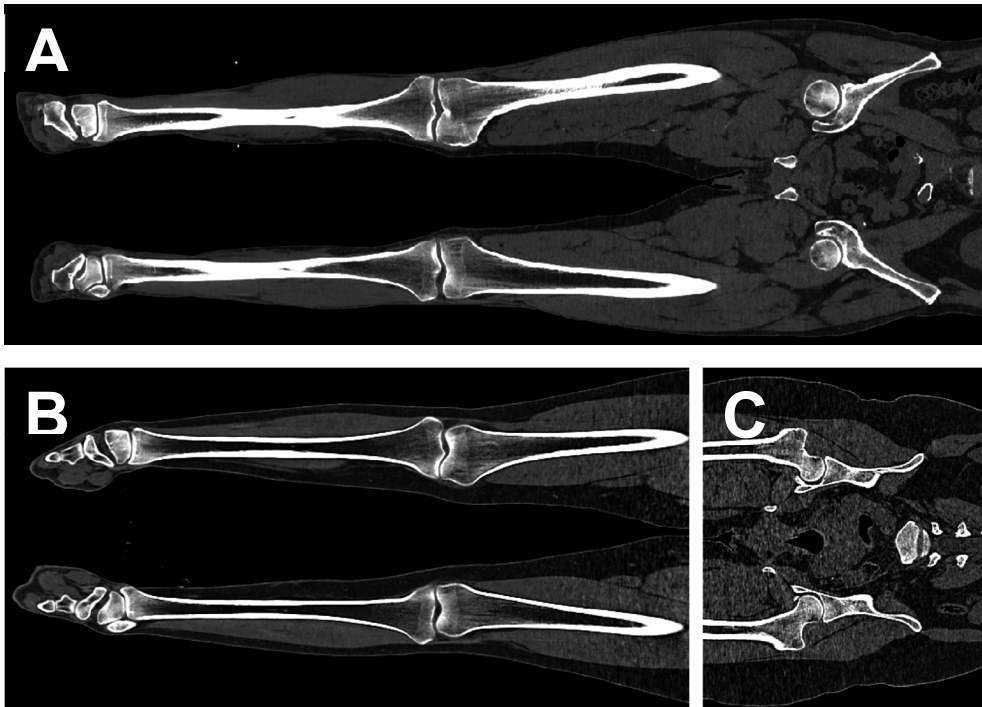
Examples of the CT scans of two patients.
